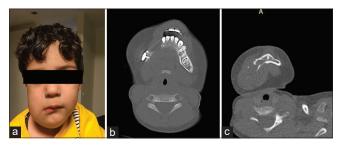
Clinical and paraclinical features of the patient. (a) Clinical view. Note facial asymmetry due to right mandibular swelling, (b) Axial view of computed tomography scan demonstrating radiolucent mandibular lesion with bone perforation and soft-tissue component, (c) The radiographic feature of the primary lesion about 1 year ago before any surgical intervention.
